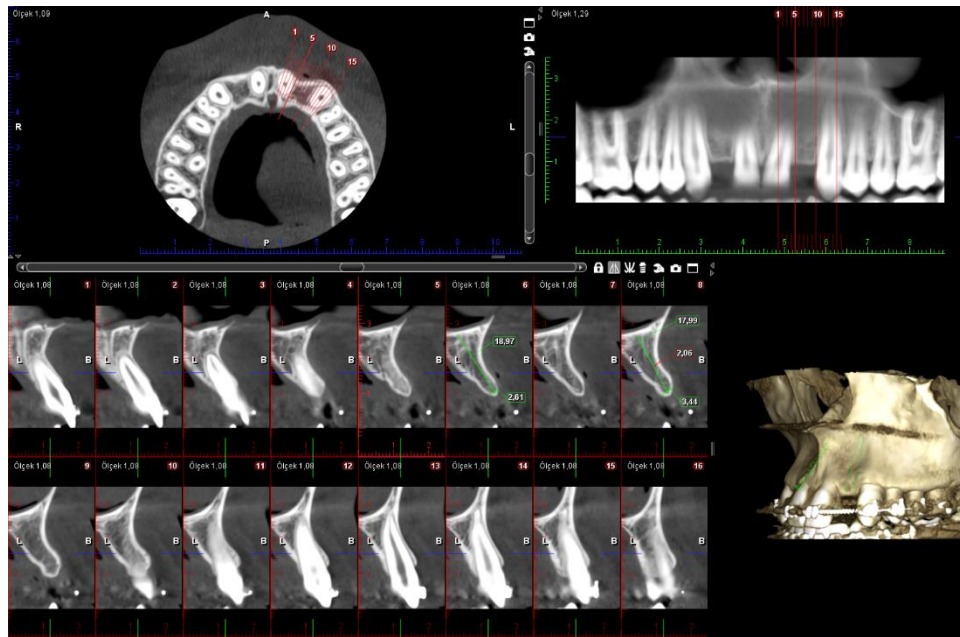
CBCT slices showing the maxillary left lateral incisor area.
